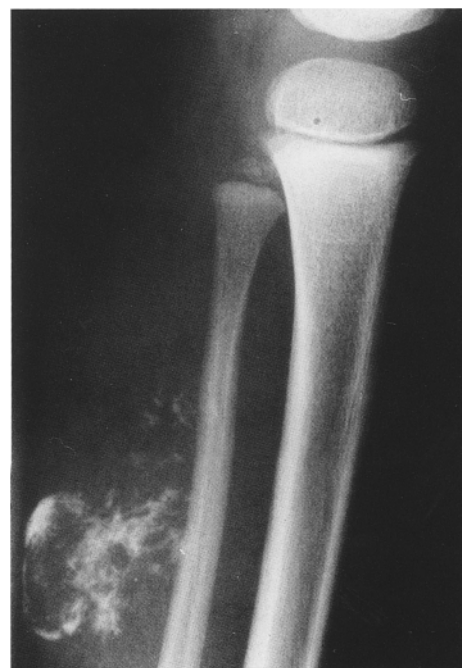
Lateral radiograph of the left leg discloses a deep soft tissue calcified tumour clearly separated from the bony shaft
